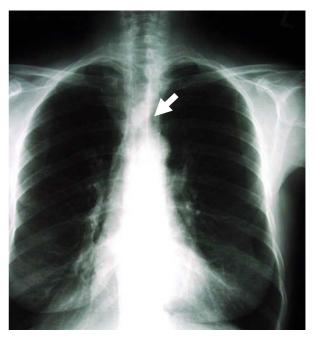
Chest x-ray demonstrated the site of tumor adjacent to the carina (white arrow)
